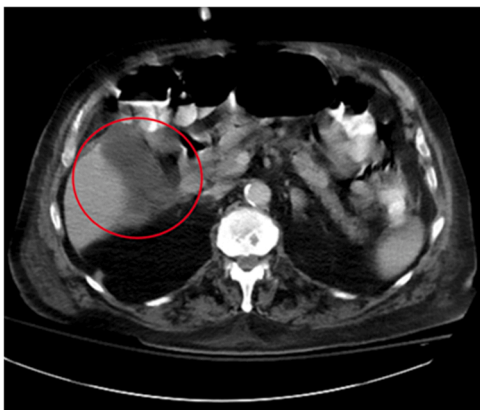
CT abdomen pelvis with IV contrast showing pericolic fluid collection.
